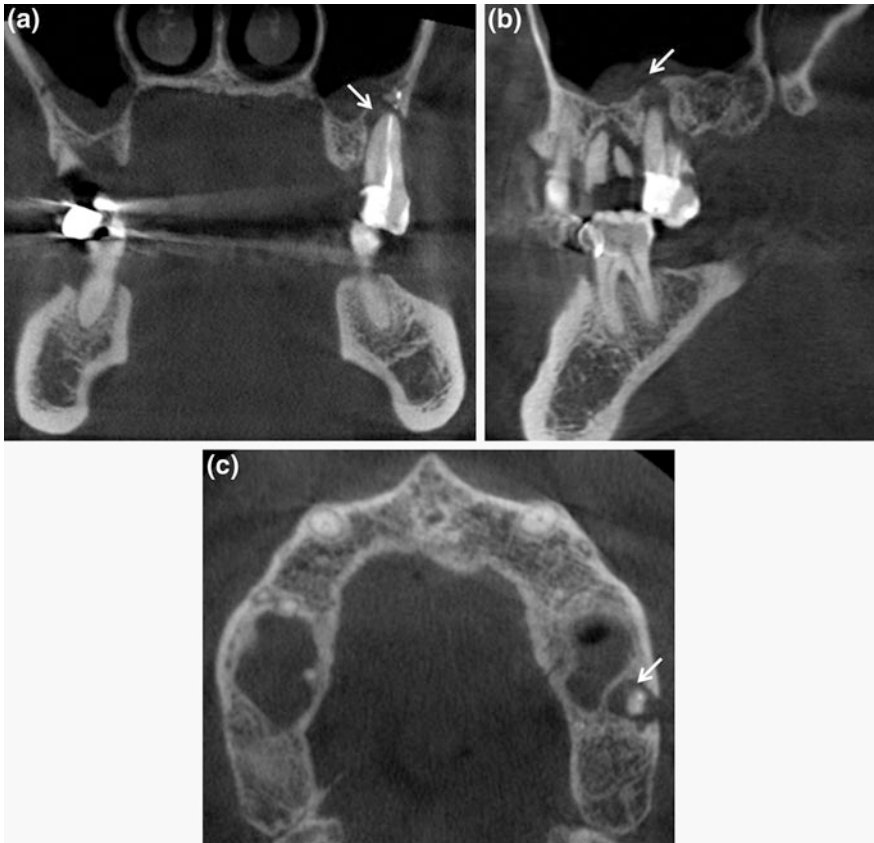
CBCT coronal (a), sagittal (b) and axial (c) sections demonstrating the presence of an extensive periradicular lesion associated with tooth 27 (*thin arrow*). Note the degree of root resorption that determinate a periapical osteolysis
